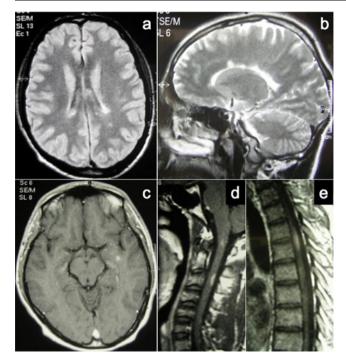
Magnetic resonance imaging (MRI) at the onset of symptoms. a Brain axial proton density sequence showing hypointense lesions of the right periventricular region. b Brain sagittal T2-weighted sequence showing multiple hyperintense lesions involving periventricular white matter and corpus callosum. c Brain, d cervical, and e dorsal spinal cord T1-gadolinium-enhancing lesions
